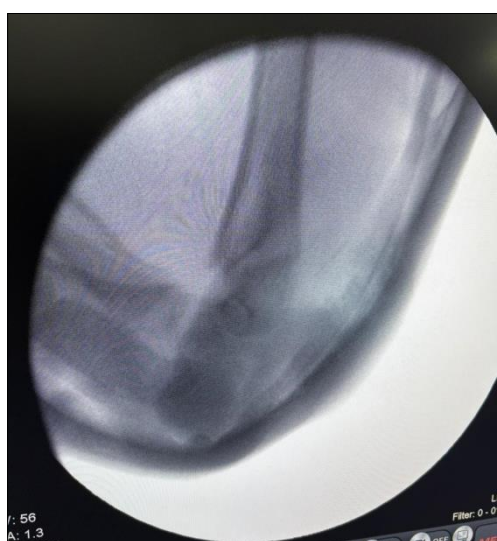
Preoperative anteroposterior and lateral radiographs showing displaced Gartland type II supracondylar fracture of the humerus in a child
